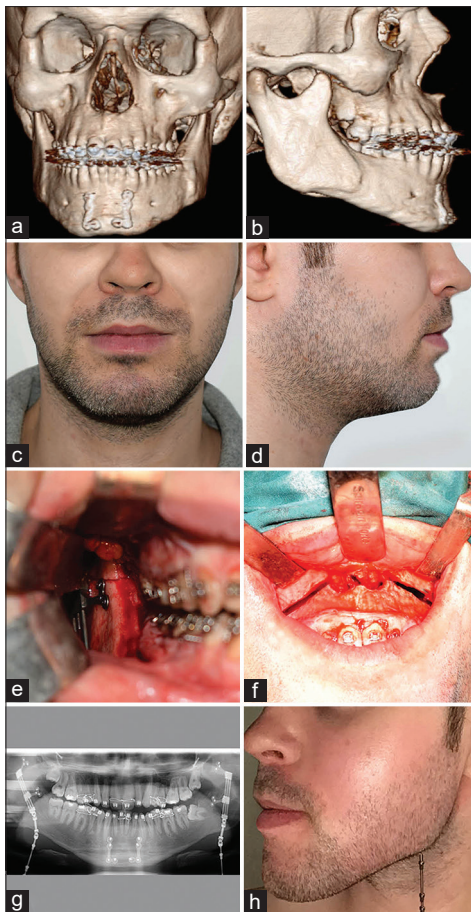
(a-d) One-year postoperative view and three-dimensional computed tomography scan showing complete bone formation with prominent zygoma and increased lower facial height. (e) Intraoperative view showing the horizontal bone cut along with mandibular ramus distractor in place. (f) Intraoperative view showing Le Fort I bone cut. (g) Postoperative orthopantomogram taken at the end of bilateral mandibular ramus distraction osteogenesis. (h) Postoperative view showing a prominent mandibular angle and increased ramus length
